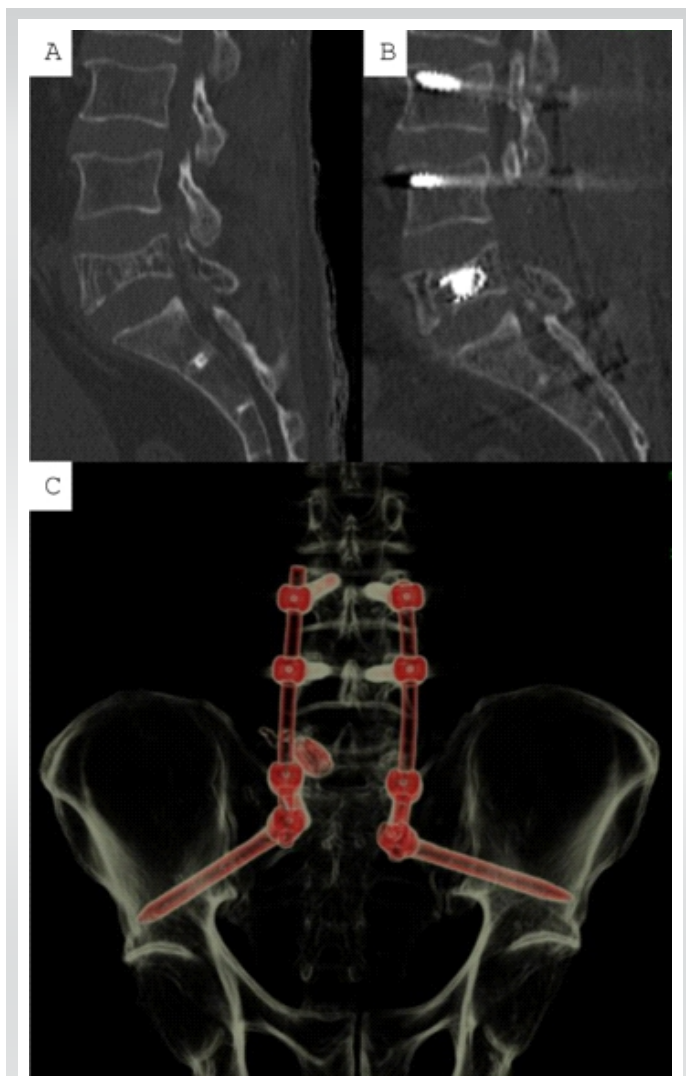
Comparison of pre-operative and 1-year post-operative computed tomography (CT) scan showing maintained vertebral height (a and b), 3-D CT reconstruction showing complete spino-pelvic instrumentation and stent (c).
